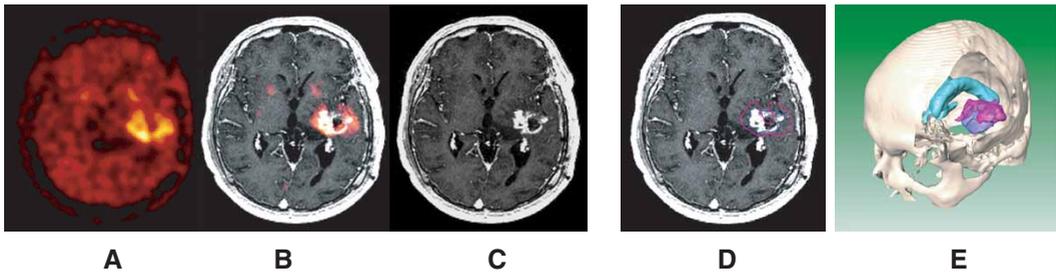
A 41-year-old male patient (No. 7) suffering from recurrent glioblastoma in the left temporal lobe. The FET-PET scan (A) shows a larger tumour extension than the corresponding Gd-enhanced MR scan (C); see also the fused image (B). The discrepancies between tumour borders, defined on the PET and MR scans, are shown in the transversal MR image (D) and in the 3D surface-based reconstruction (E). The blue-coloured line/surface marks the MRI-based tumour borders and the rose-coloured line/surface marks the PET-based tumour borders. The green-coloured surface in the image E marks the ventricular system.
